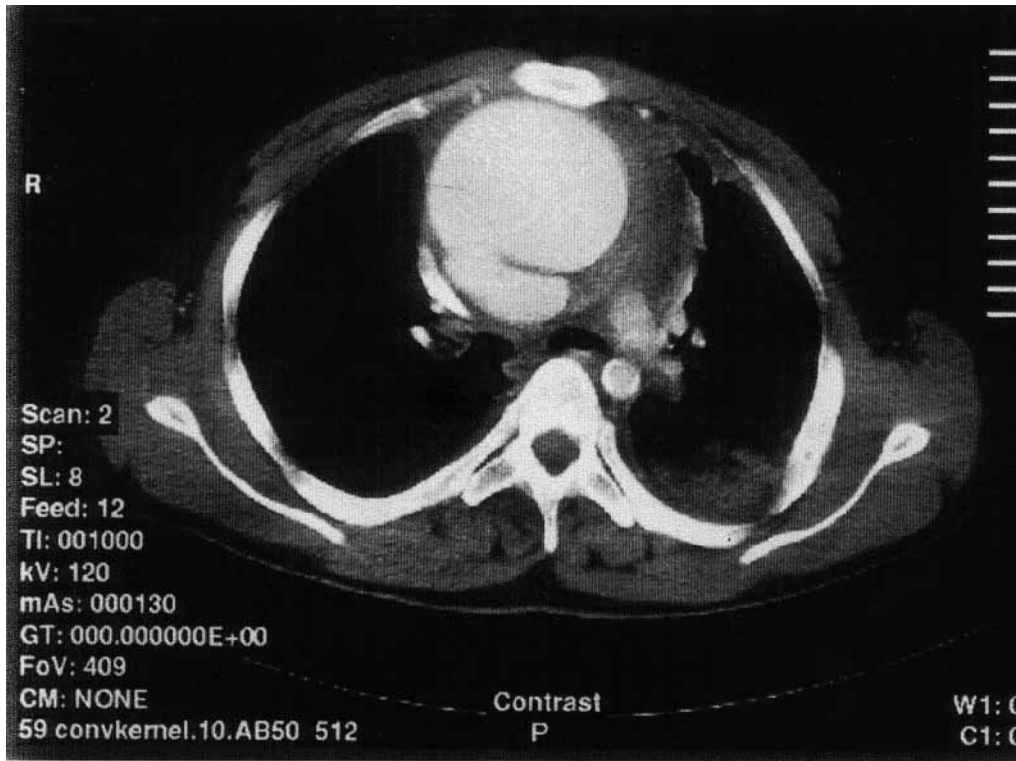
Computed tomographic scan of thorax showing type II aortic dissection and coarctation.
